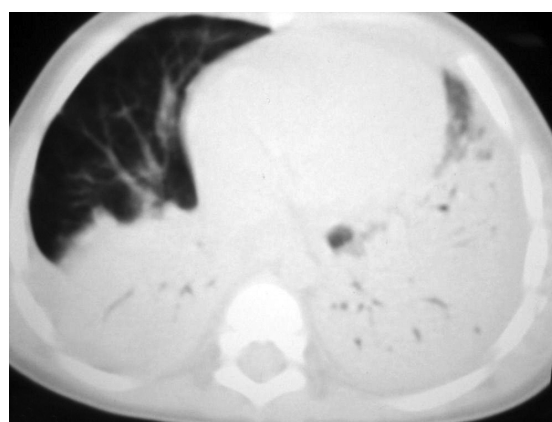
CT image of the thorax shows consolidation of the lung, predominantly in the gravity-dependent areas.
